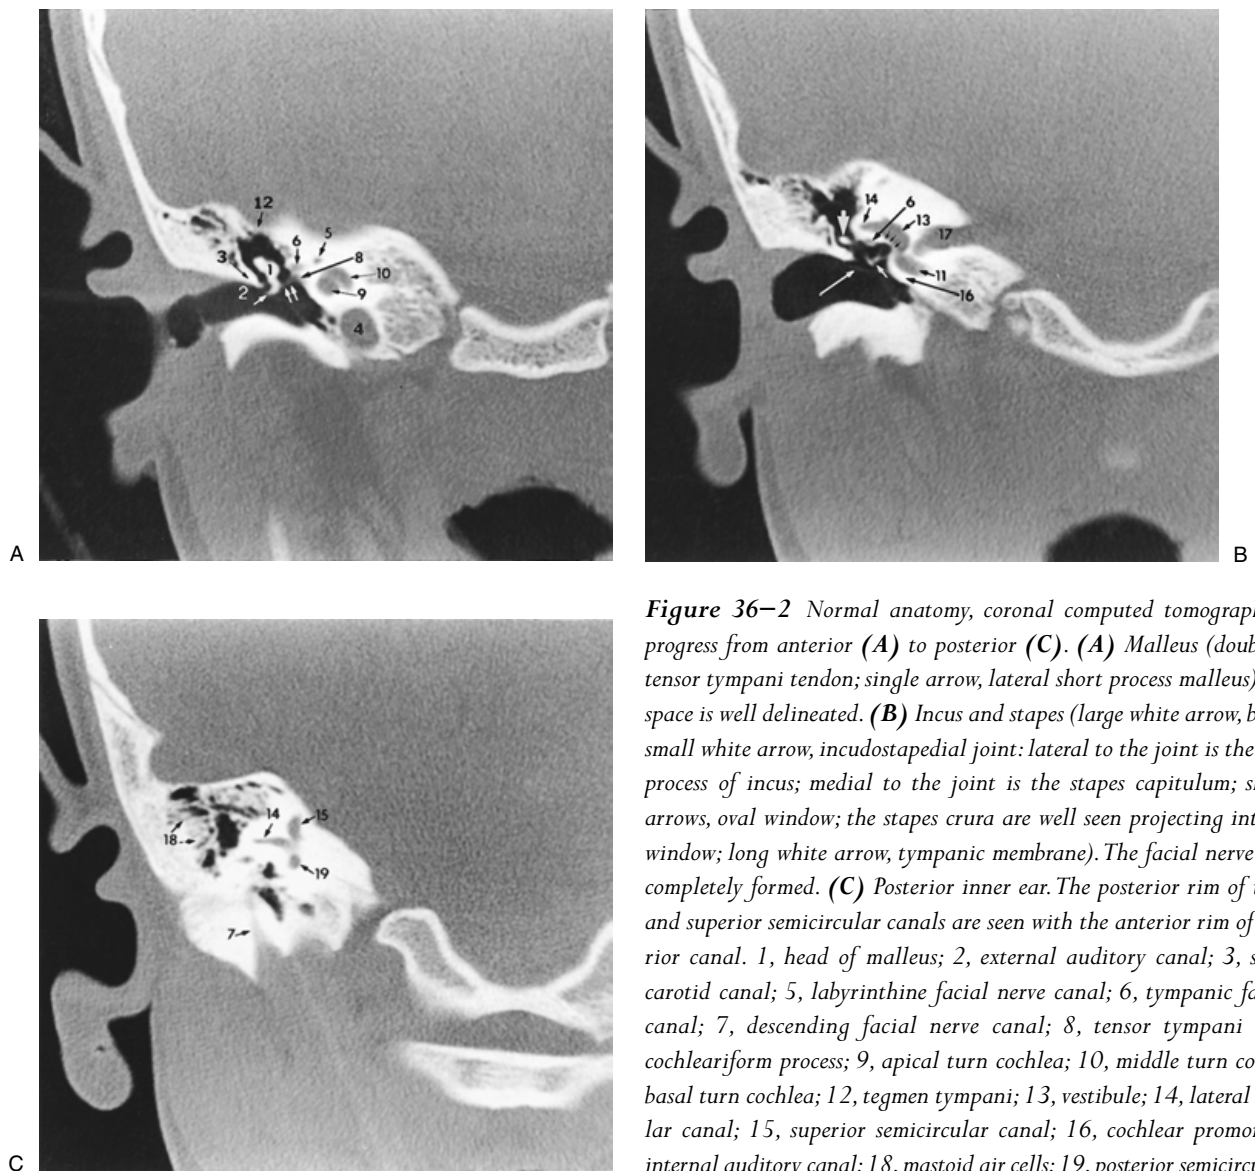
Normal anatomy, coronal computed tomography. Images progress from anterior (A) to posterior (C). (A) Malleus (double arrows, tensor tympani tendon; single arrow, lateral short process malleus). Prussak's space is well delineated. (B) Incus and stapes (large white arrow, body incus; small white arrow, incudostapedial joint: lateral to the joint is the lenticular process of incus; medial to the joint is the stapes capitulum; short black arrows, oval window; the stapes crura are well seen projecting into the oval window; long white arrow, tympanic membrane). The facial nerve canal has completely formed. (C) Posterior inner ear. The posterior rim of the lateral and superior semicircular canals are seen with the anterior rim of the posterior canal. 1, head of malleus; 2, external auditory canal; 3, scutum; 4, carotid canal; 5, labyrinthine facial nerve canal; 6, tympanic facial nerve canal; 7, descending facial nerve canal; 8, tensor tympani muscle at cochleariform process; 9, apical turn cochlea; 10, middle turn cochlea; 11, basal turn cochlea; 12, tegmen tympani; 13, vestibule; 14, lateral semicircular canal; 15, superior semicircular canal; 16, cochlear promontory; 17, internal auditory canal; 18, mastoid air cells; 19, posterior semicircular canal.
